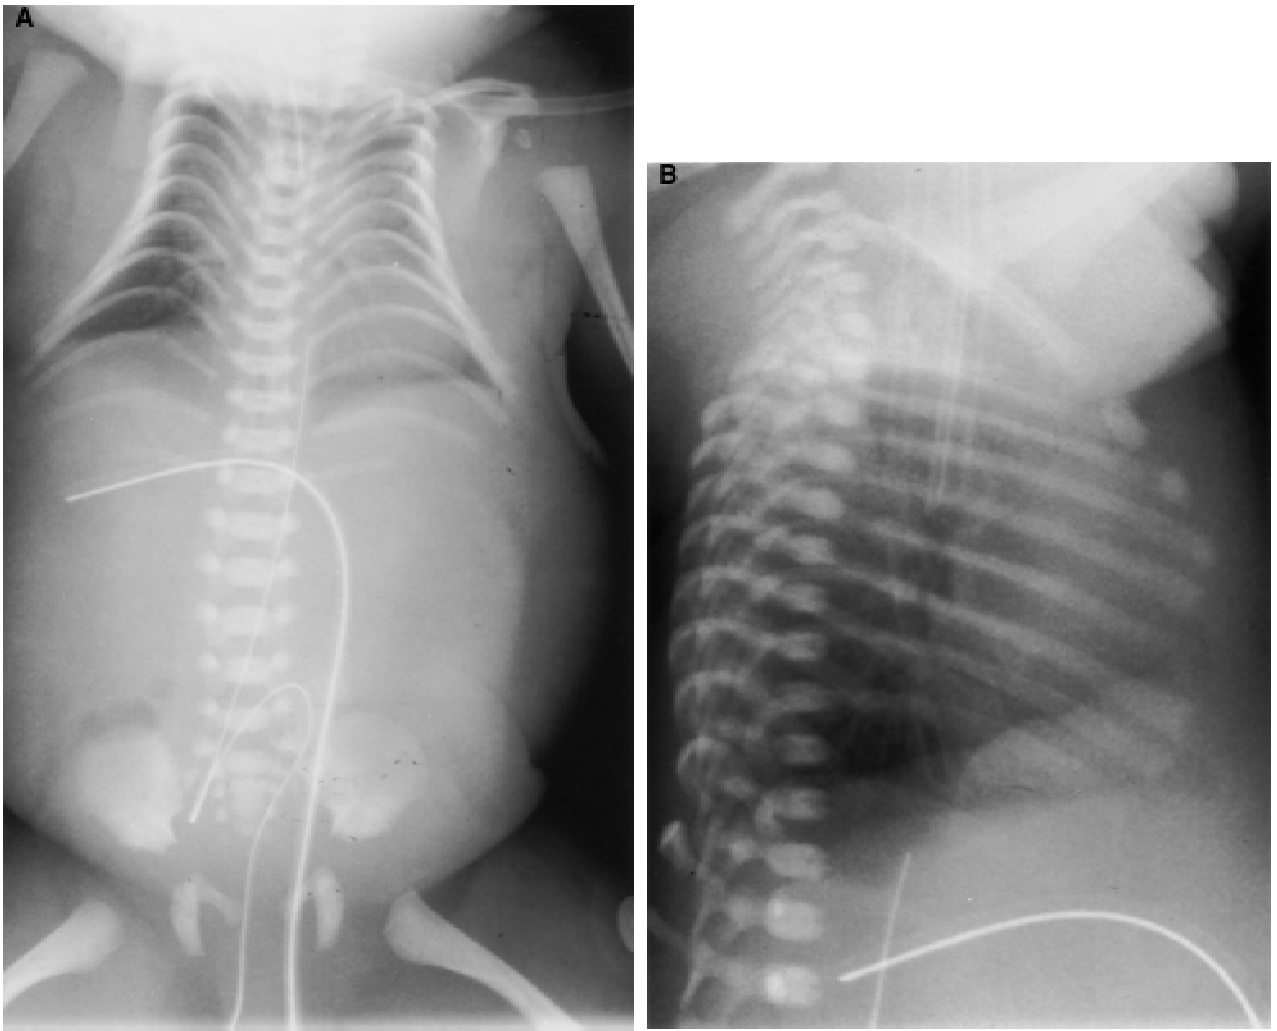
A: AP and (B) lateral radiographs demonstrating the small bell-shaped thorax with hypoplastic ribs and elongated clavicles.
